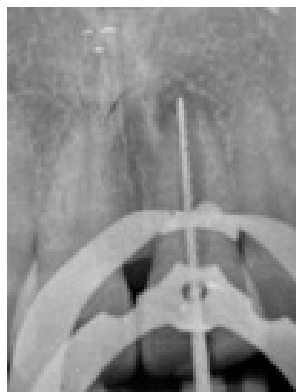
#40 Hedstrom file was used to penetrate the periapical tissue.
